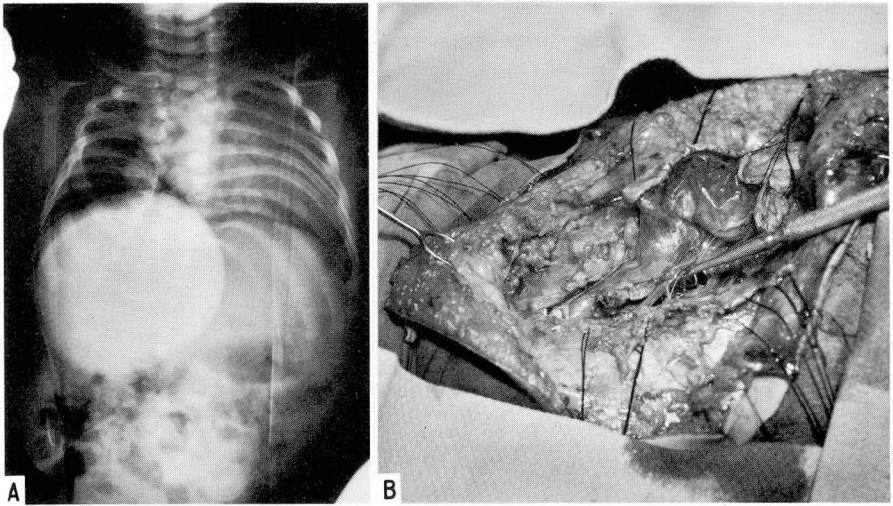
Case 5, A, Roentgenogram revealing evidence of bilateral hemivertebra of the thoracic spine. The round pale area represents the meningocele. The meningocele is poorly outlined above it. B, Surgical exposure, case 5. Patient's head is toward the left. A spatula is elevating the left hemicord and stretching its nerve roots. The end of the instrument touches the midline bony spur. Note how the hydromyelic right hemicord expands to constitute the sac of the syringomyelocele, its skin edge retracted by sutures. The pale area at the upper end of the exposed hydromyelic cord indicates the level of the neck of the meningocele.
